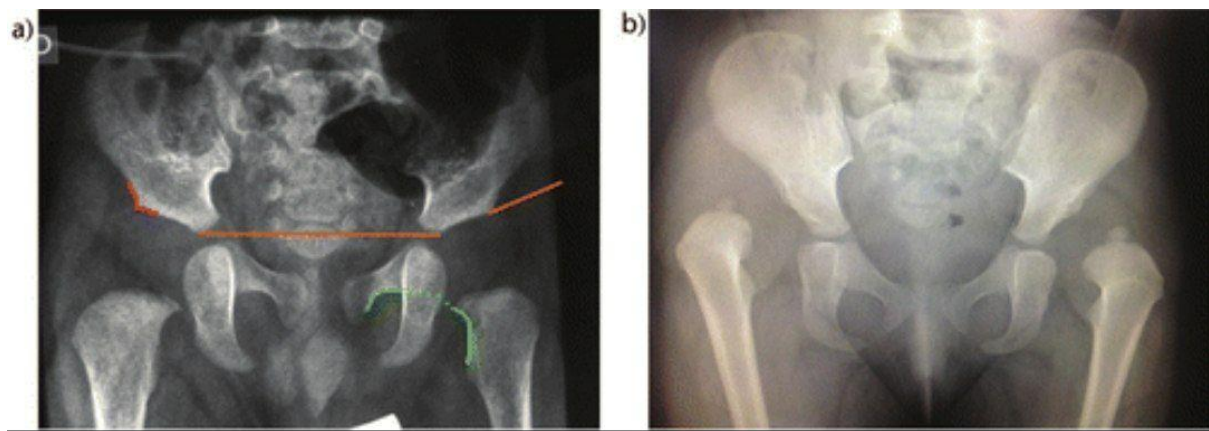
(a) Radiograph studies are the reference in children older than 4 to 6 months of age. In the image, although the ossification nucleus of the head is absent, indirect signs of concentric reduction as the formed talus (red line) and Shenton line (green lines) are present. The acetabular index (orange line) is the main parameter to control acetabular development during the first years of age. (b) Bilateral dislocation of a two-year-old child.
